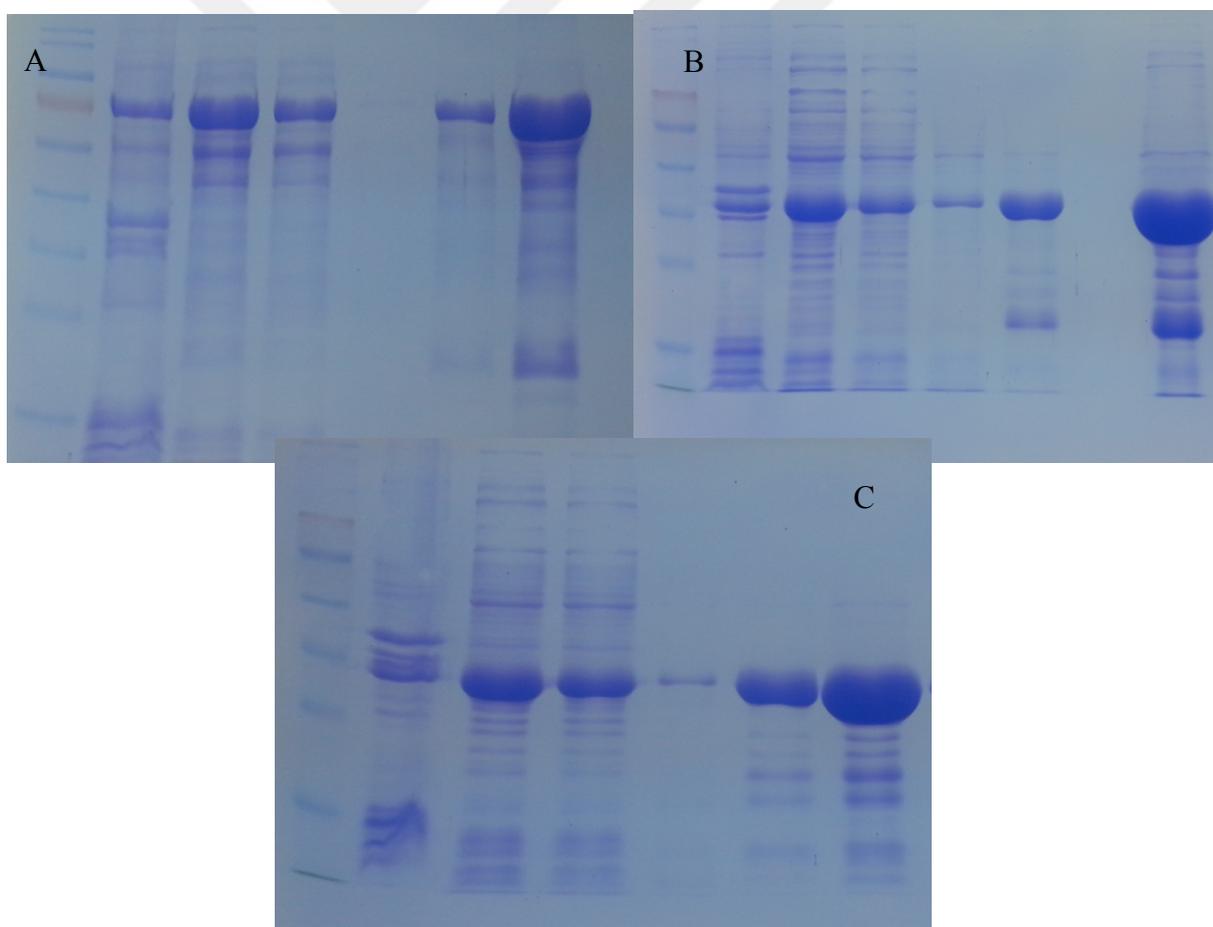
SDS-Page analysis after expression. Samples were loaded as pellet and supernatant respectively. H, 6XHis; S, SUMO protein; NP, nucleoprotein of CCHFV; NT; N-terminal part of NP; CT, C-terminal part of NP).
